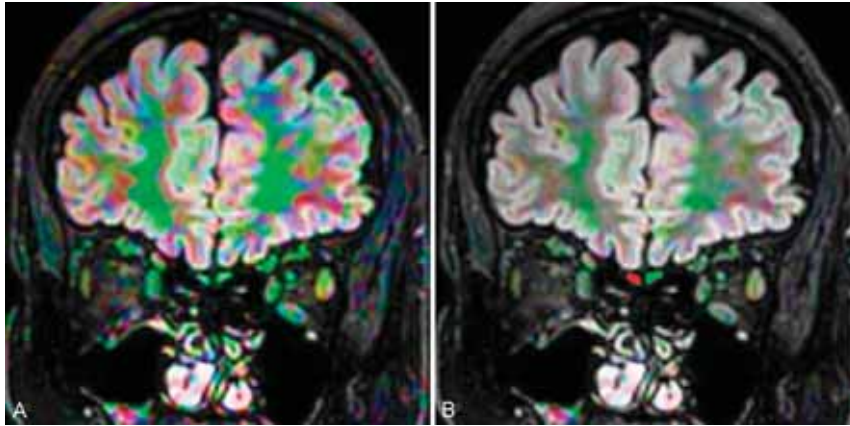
The OB in a patient with COVID-19-related anosmia. DTI of the OB with displays on the 3D-FLAIR image. The mean MD and FA of the OB values were 1.97 mm²/s and 0.18, respectively.
